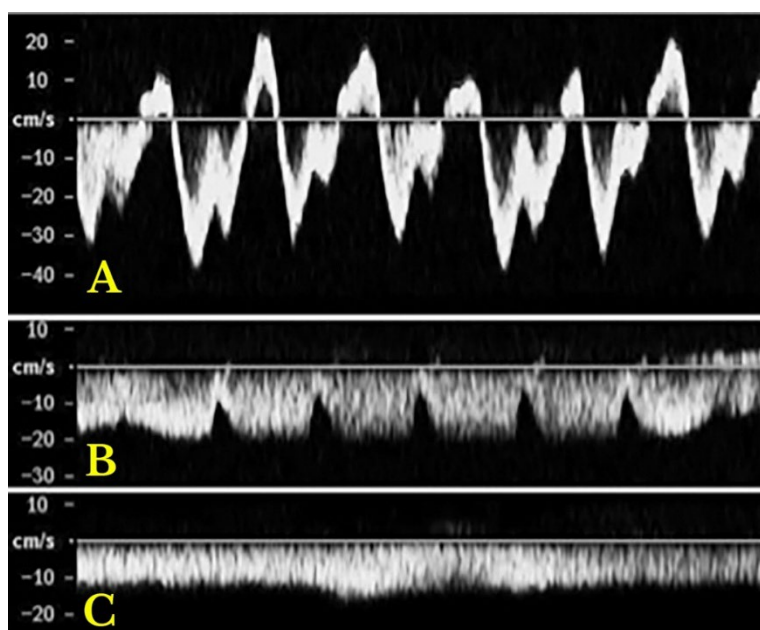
Hepatic vein Doppler waveforms are used to assess blood flow in the hepatic veins. A normal waveform is triphasic (A), characterized by two hepatofugal peaks (flow away from the liver) and one hepatopetal peak (flow towards the liver) at the top of the panel. Abnormal waveforms include: Biphasic (B): Lacks the hepatopetal peak, indicating altered flow dynamics, often associated with portal hypertension. Monophasic (C): Shows a flat waveform, indicating significant disruption to normal blood flow, often seen in advanced portal hypertension or other severe vascular conditions.
